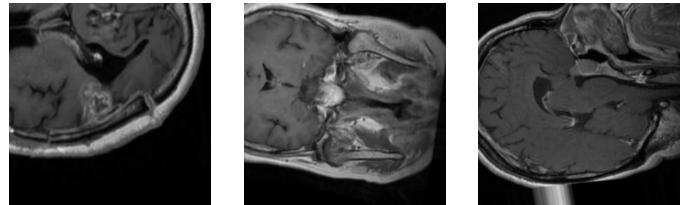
Preprocessed sample images from MRI scans
